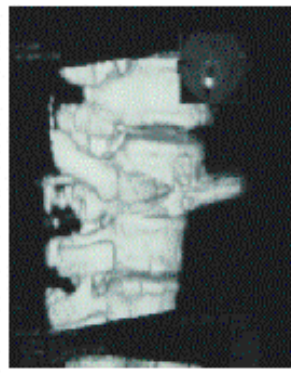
CT scan, 3D reconstruction Sagittal view. Shows bullet
